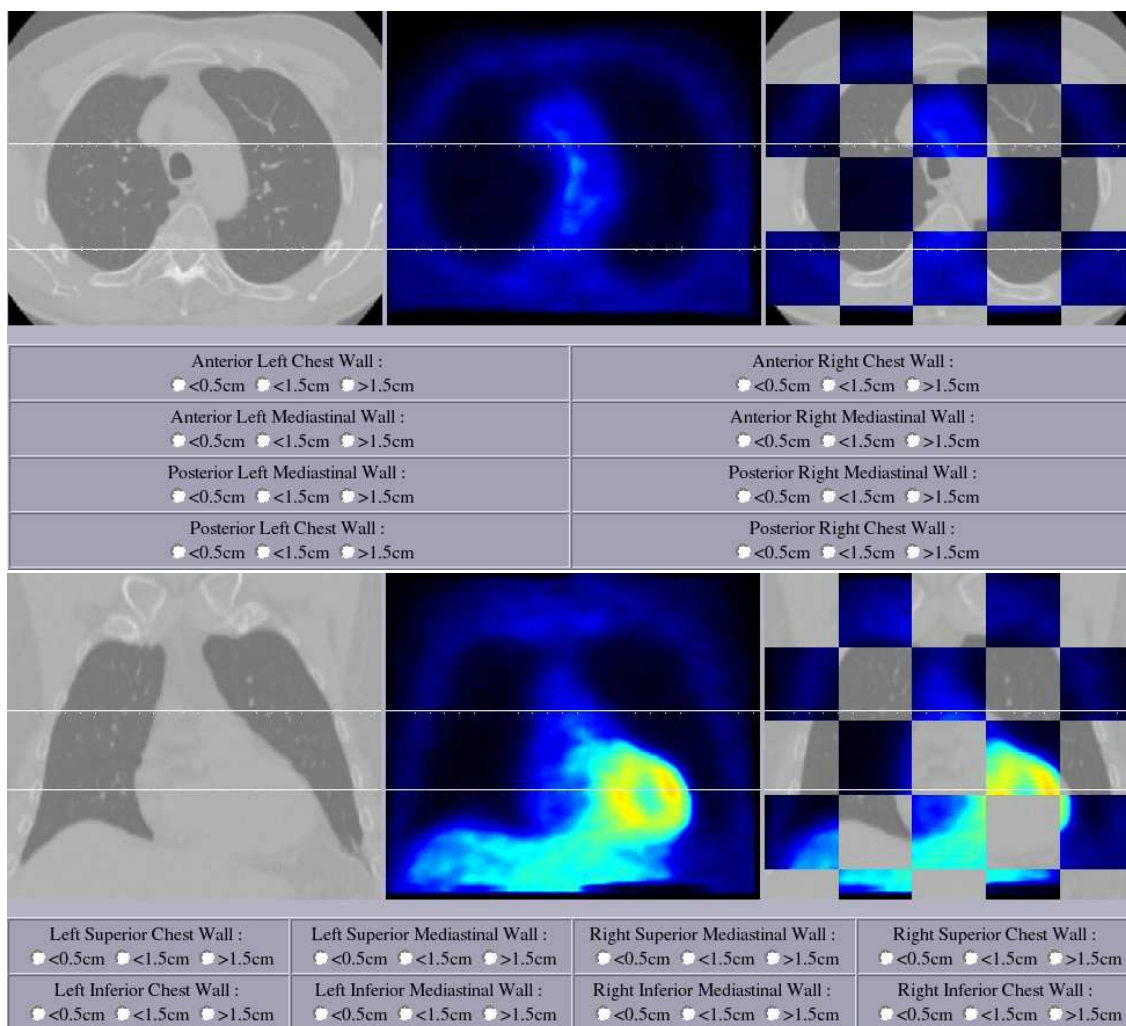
Example of 2D axial (top) and coronal (bottom) slices of the CT (left), registered PET (center) volumes and the chessboard display (left) used in the visual assessment protocol. They are marked with the rulers (white) that define landmark points where registrations must be evaluated.
